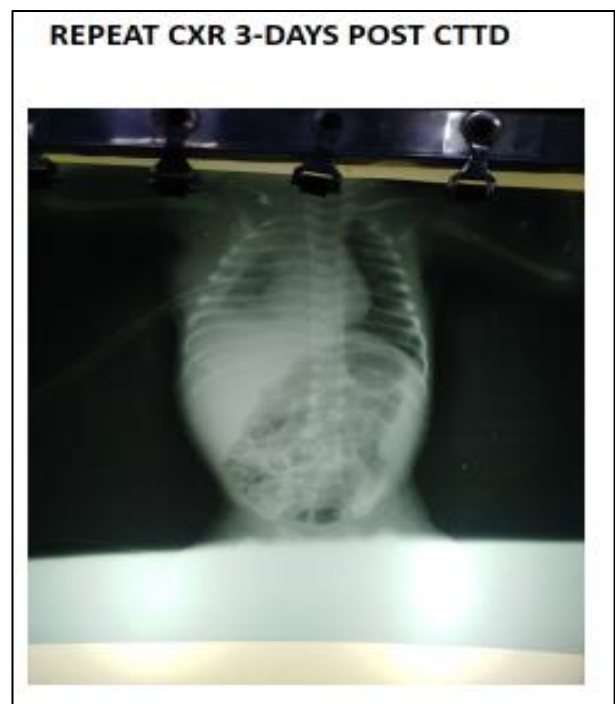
Chest X-ray 3 days post CTTD.
